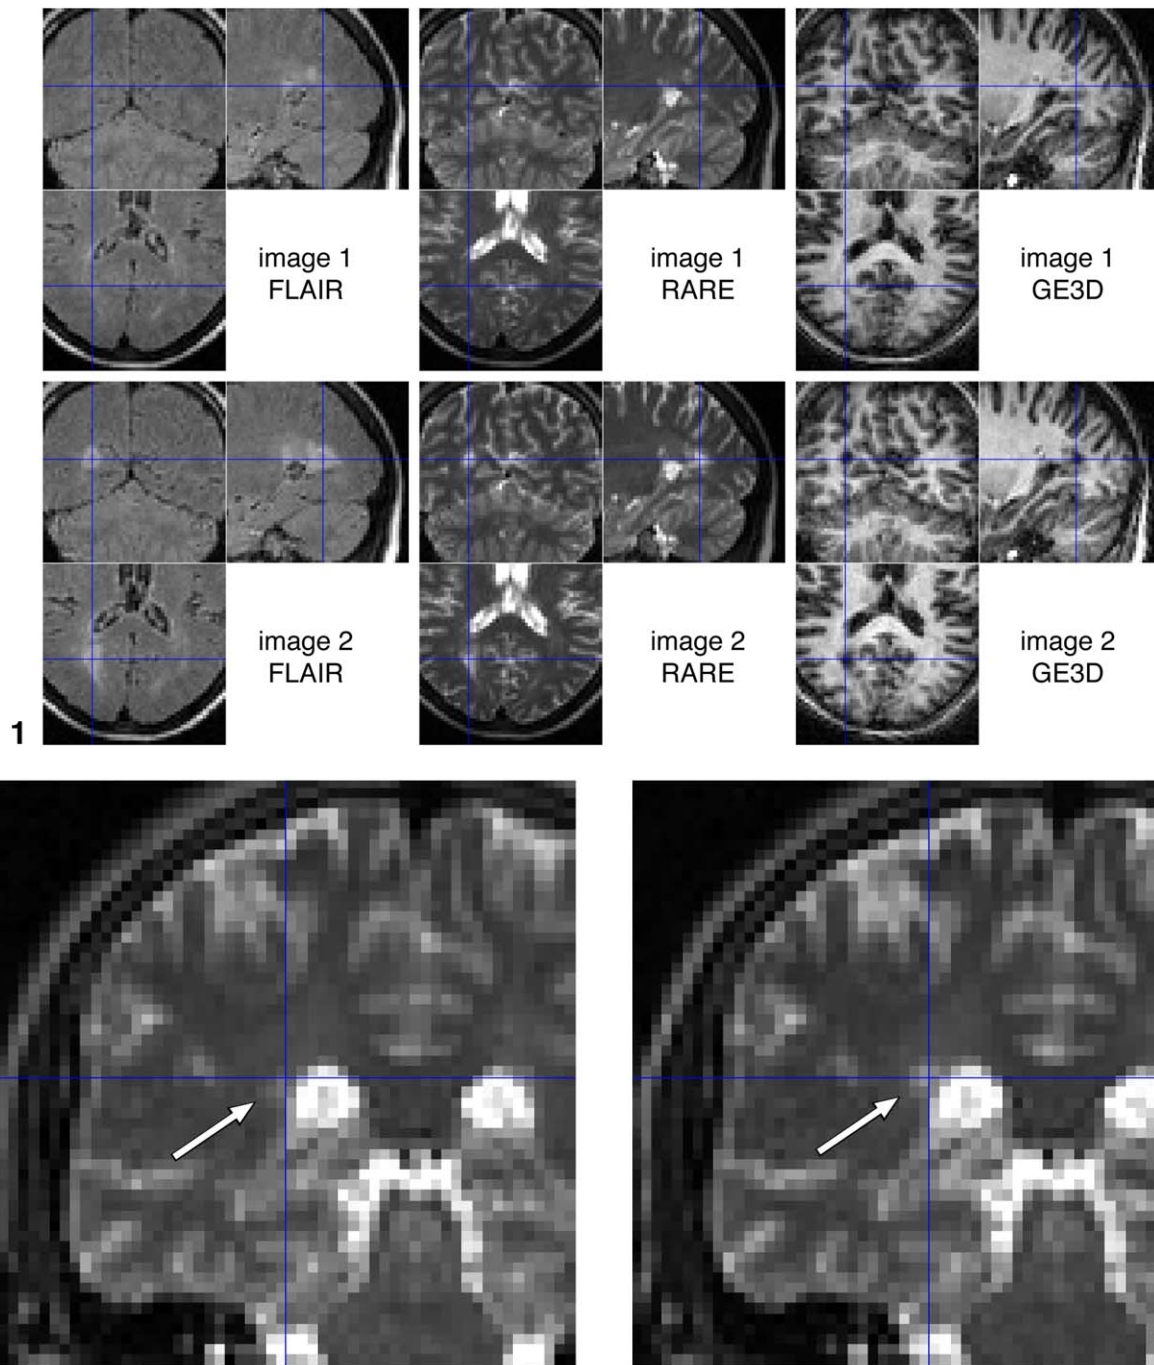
Large evolution of an MS lesion in 3 different modalities (FLAIR, RARE, and GE3D). The images labeled “2” were taken 2 months after the images labeled “1”. Lesion evolutions of this size are easily detected by manual or automatic methods (lesion is visible at cross hairs).
